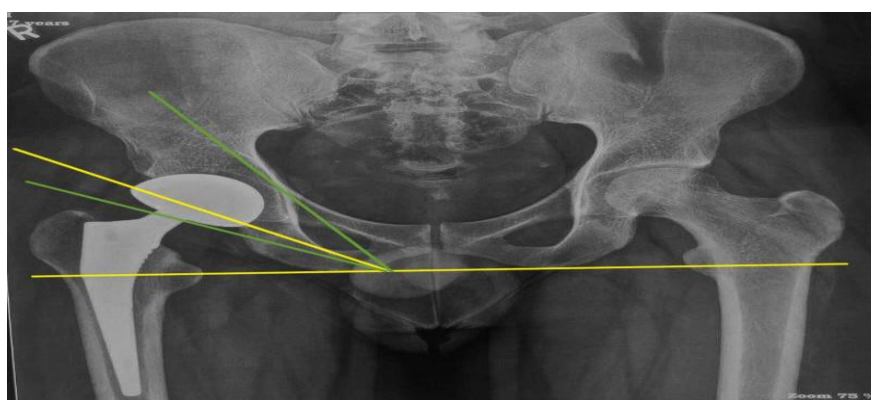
Post-op Xray of patient showing acetabular inclination (38 degrees) between the yellow lines with green lines depicting the safe zone for inclination (30-50 degrees).
